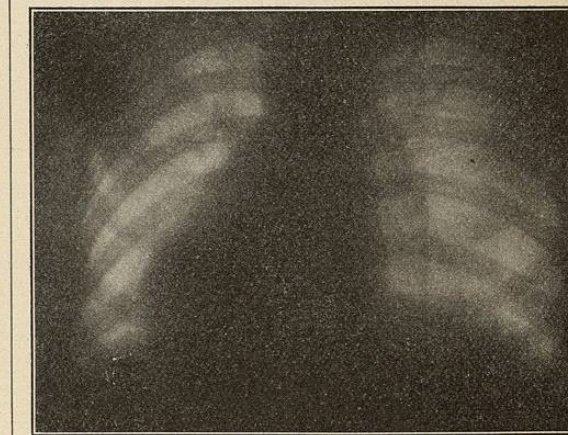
Radiograph showing Transposition of the Heart to the Right Side. (Schüppel's case.)
